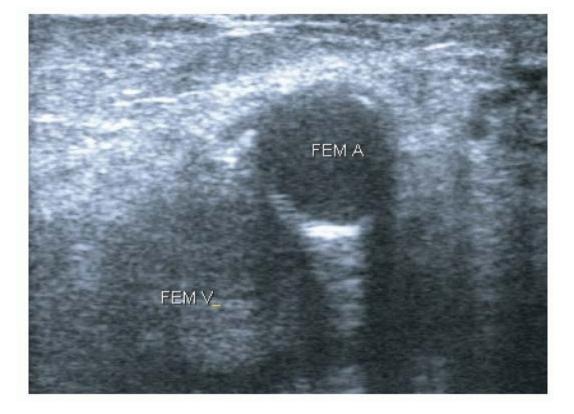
Ultrasound showing a transverse view of the femoral artery and vein. The lumen of the femoral vein (deep and medial to the artery) is occluded by thrombus, giving a hyperechoic signal compared to the arterial lumen.
